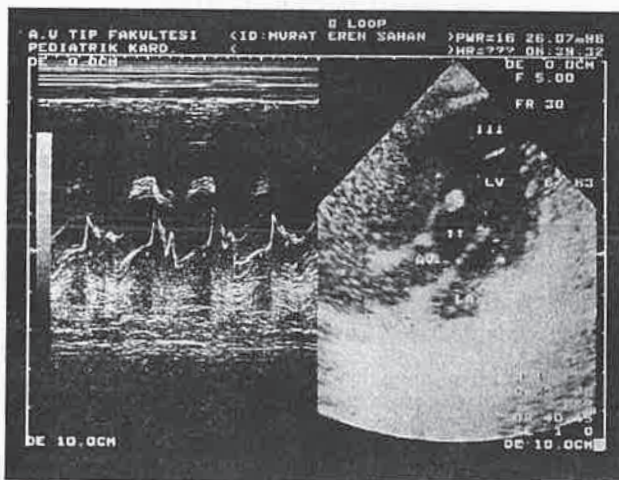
Apical long axis echocardiogram from patient. An 8x8 mm mass (double arrows) is attached to the ventricular septum in the left ventricular outflow tract. AV = aortic valve, LA = left atrium, LV = left ventricle.
